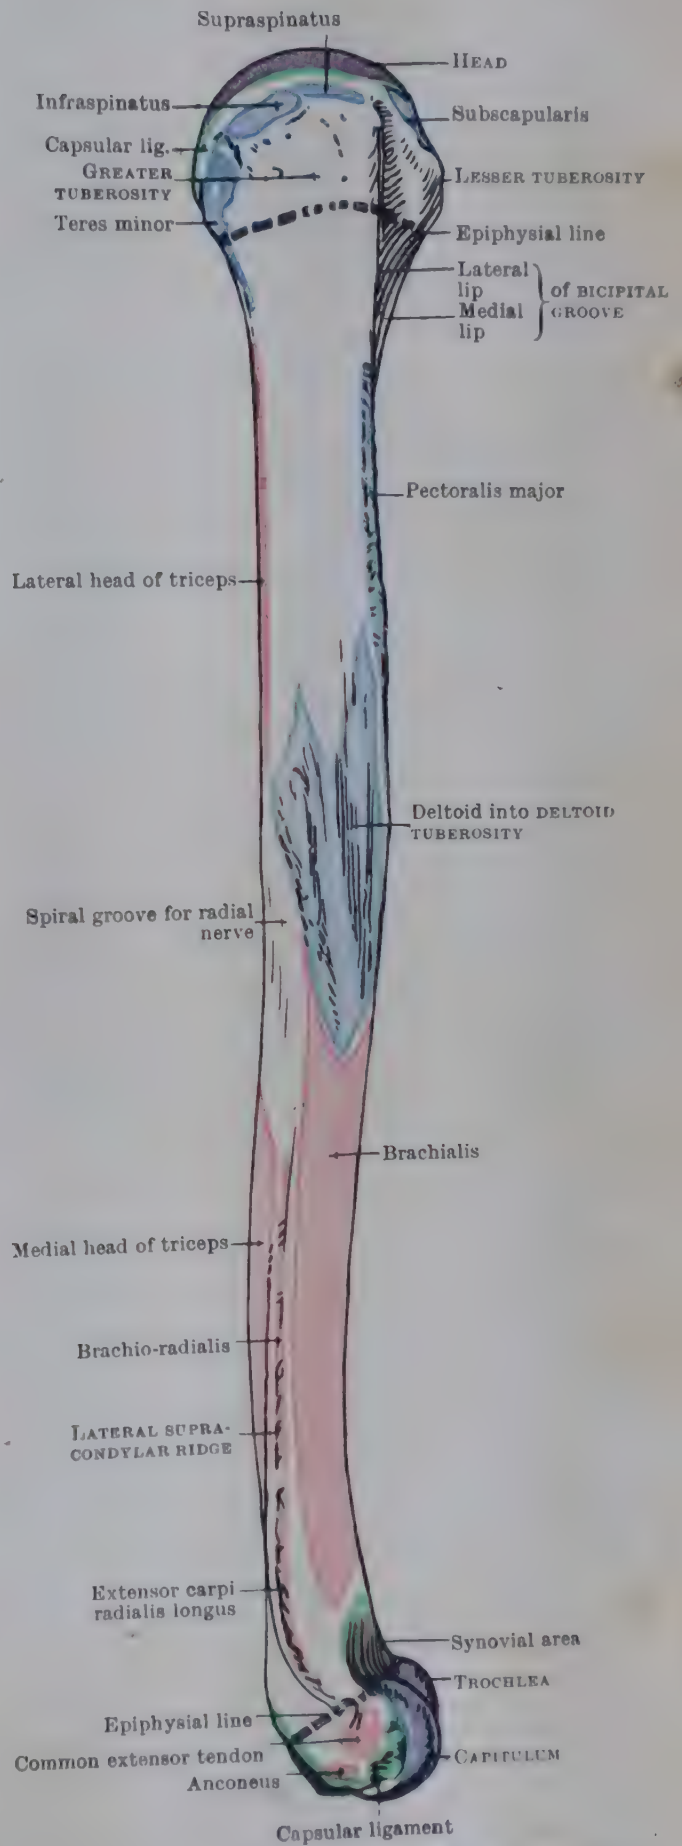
LATERAL ASPECT OF RIGHT HUMERUS.
